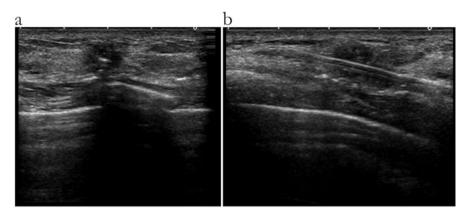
Intraoperative breast ultrasound. (a) Cool-TipTM RF needle electrode is seen traversing the breast tumor. (b) Needle is seen "end-on" and noted to be in the center of the lesion
